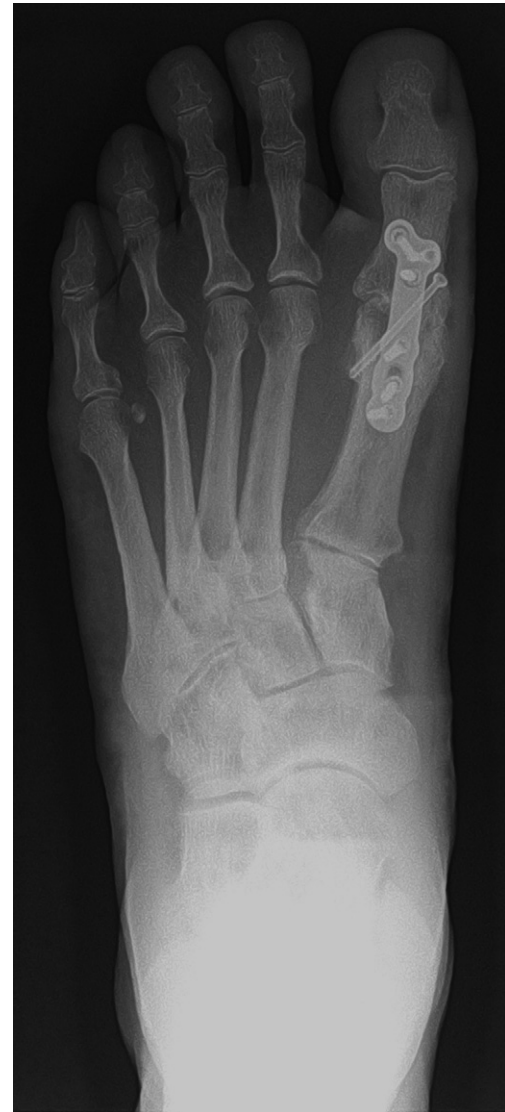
Arthrodesis. Postoperative dorsal-plantar radiographic view demonstrating result of arthrodesis of first metatarsophalangeal joint using a plate and a single partially threaded cortical lag screw.
